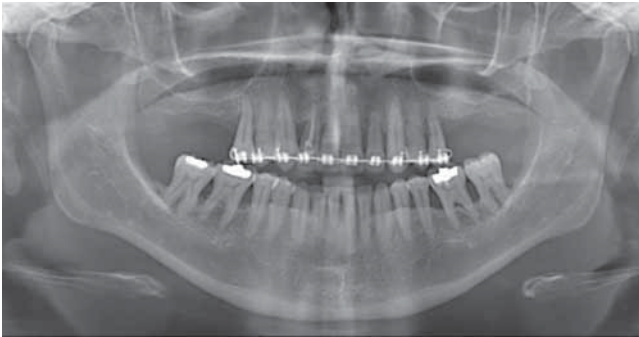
Control radiographic view where stability in root surfaces can be observed without resorption as well as better alignment.
